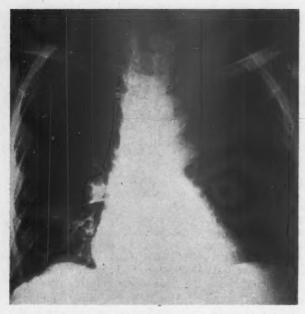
Thin rim of calcification visualized on clinical x-ray film (from 4 to 6 o'clock of aortic arch).
